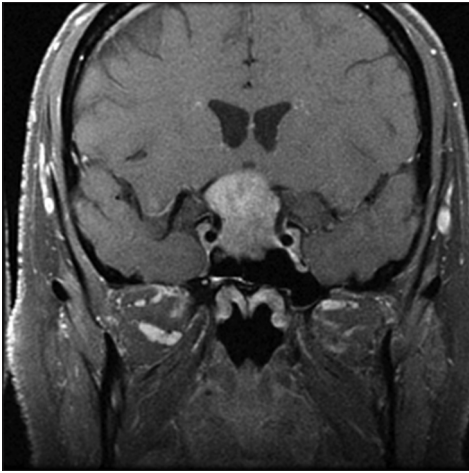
Preoperative magnetic resonance imaging showing a pituitary macroadenoma
